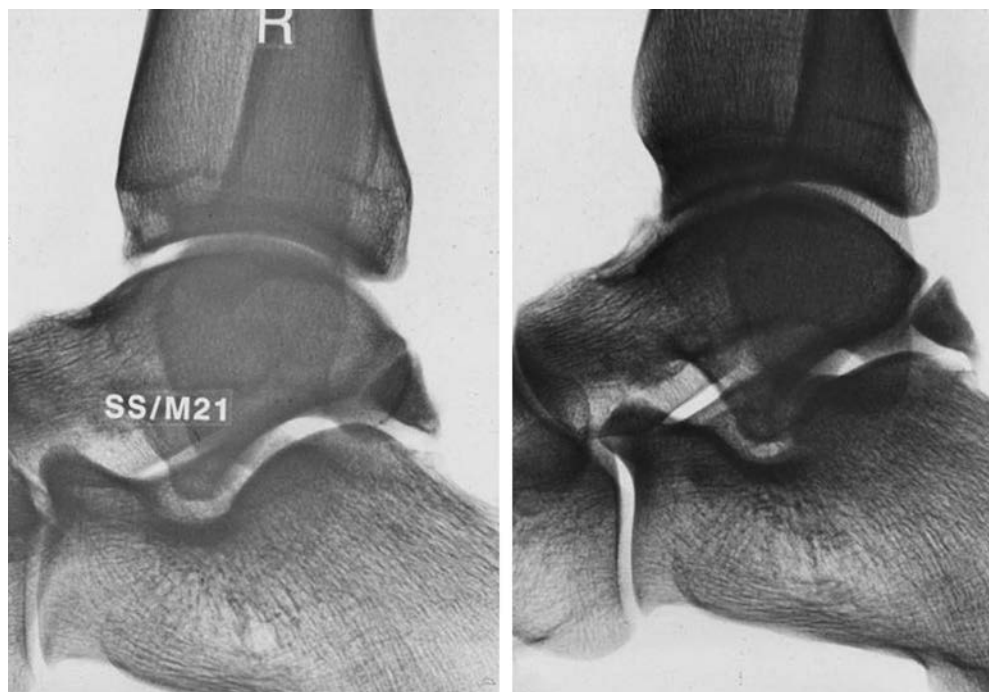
Posttraumatic syndrome of the os trigonum of the right ankle. Plain lateral x-rays (*left*) reveal an undisrupted os trigonum. Additional posteromedial impingement views (PIM) with the foot in 25-degrees external rotation in the same patient show that the os trigonum is disrupted.
